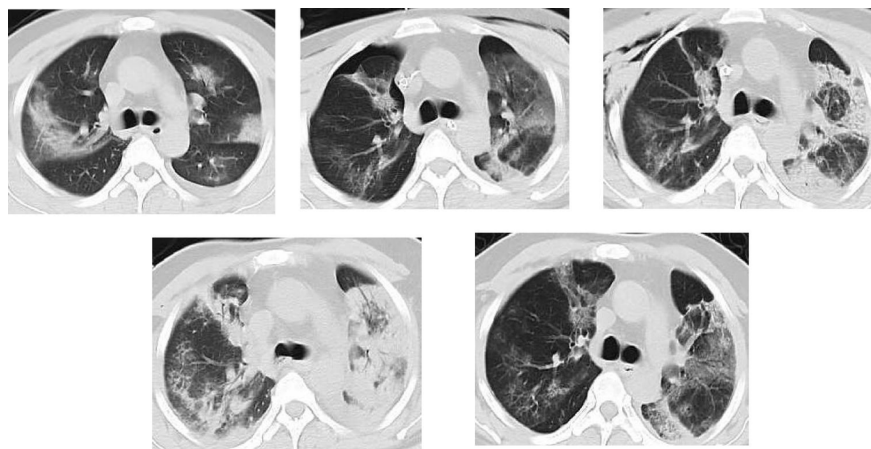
Lung computed tomography (CT) from day 8, 21, 26, 31, and 37, respectively. These images suggest that the lesions in both lungs progressed in the first month of the disease course. The last CT shows significant improvements in both lung lesions.
